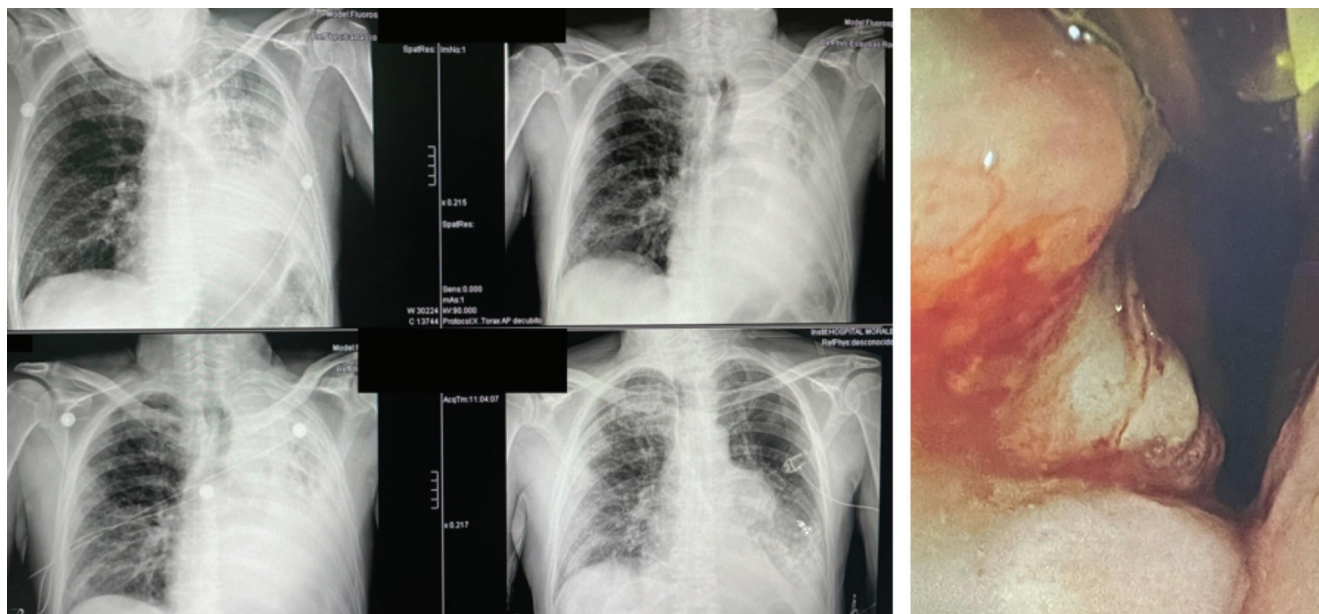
A 63-year-old male patient (left lung) with acute respiratory failure. BiLevel ventilation (IPAP: 25 cmH₂O; EPAP: 8 cmH₂O) during bronchoscopy. Chest X-rays at the start of the treatment (top images, the left with facial mask application), during (bottom left), and after the bronchoscopy (bottom right), with no endotracheal intubation
